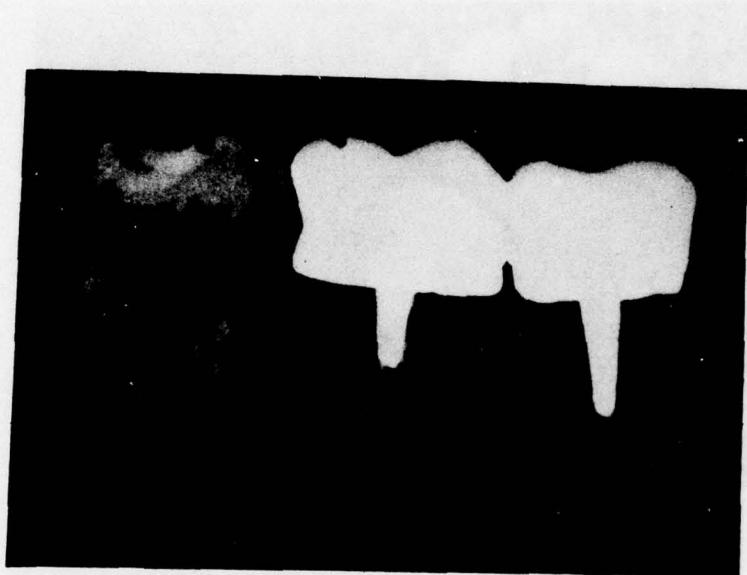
RADIOGRAPH OF IMPLANTS IN FUNCTION
